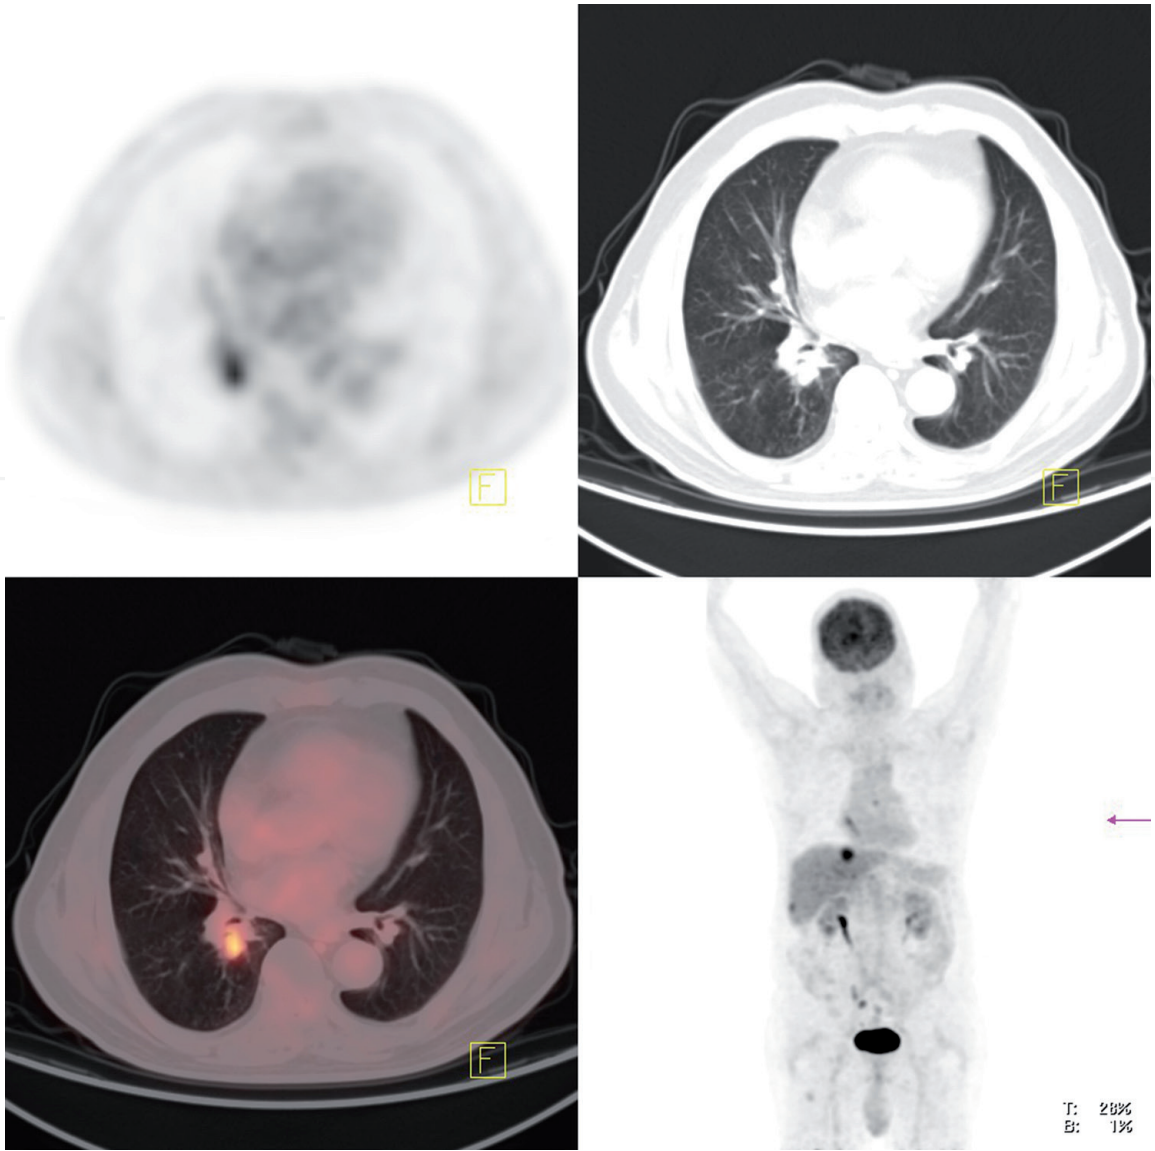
Axial PET, CT, PET-CT, and MIP images in a patient of squamous cell carcinoma. An irregular mass showing moderate FDG uptake in the lesion was discovered in the central segment of the right lung, with inflammation around the malignant lung lesion.
